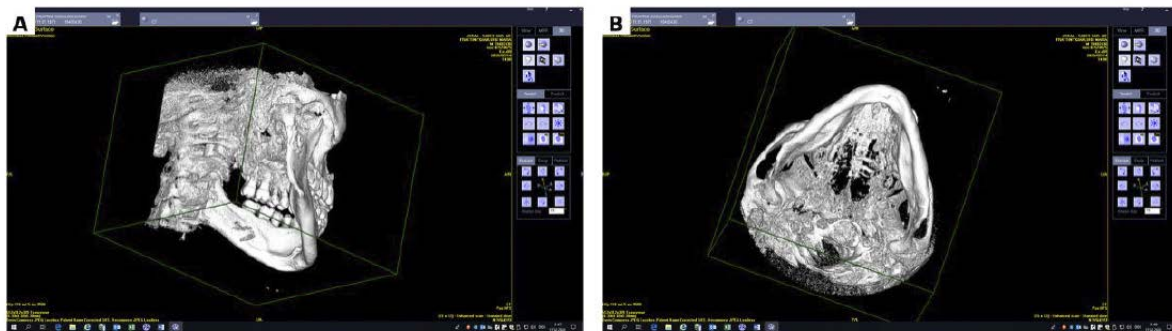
Postoperative three-dimensional CBCT reconstructions documenting fracture reduction and plate positioning. A, lateral view. B, inferior/axial view.
